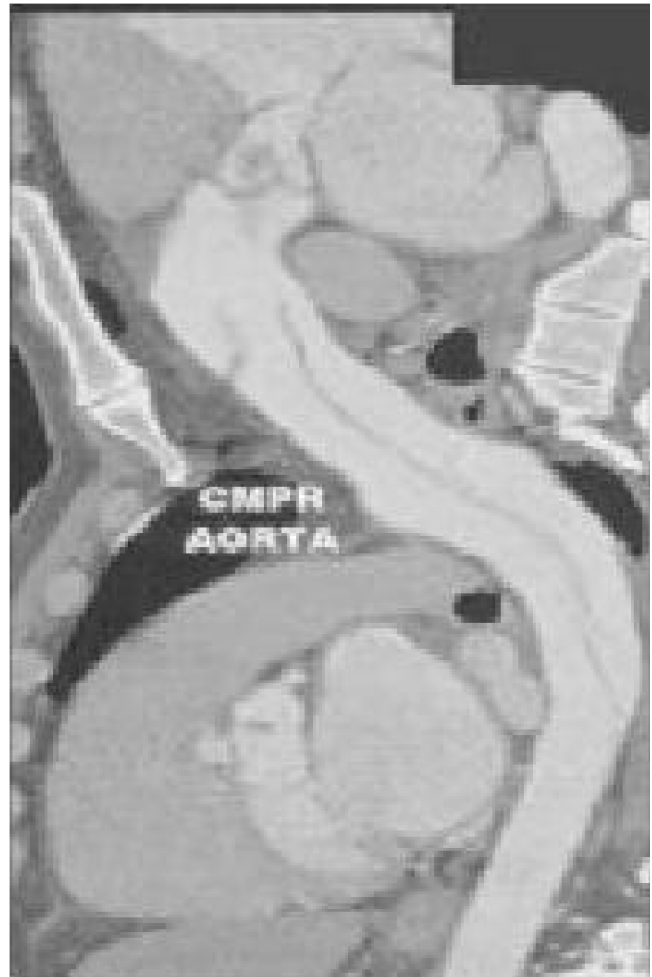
Pre-operative: Acute ascending aortic dissection as seen on CT angiography.
